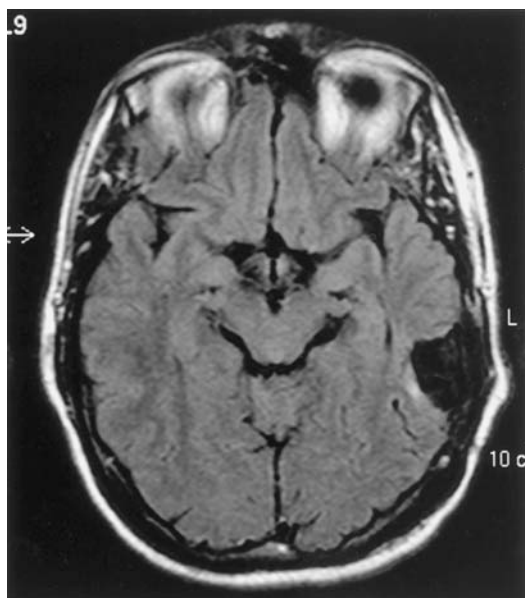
Case MB 9 years after surgery. The small area of high signal on this FLAIR sequence has remained unchanged since surgery and presumably represents gliosis.
